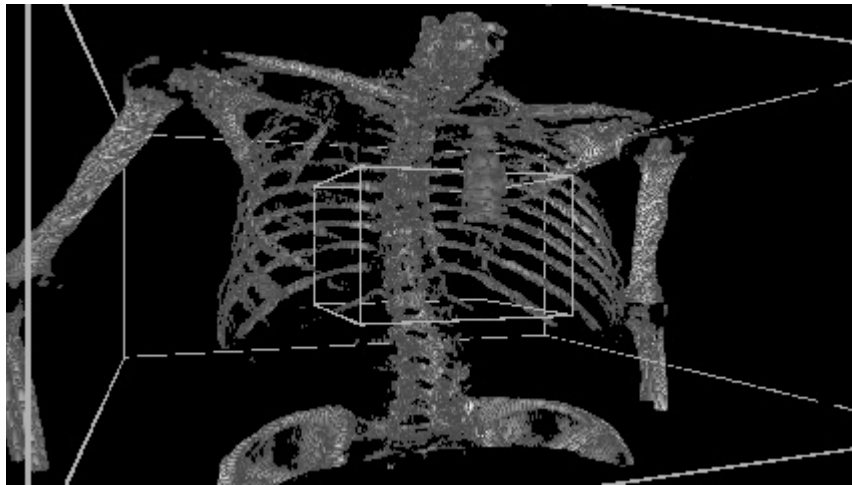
Original left CT perspective projection.
